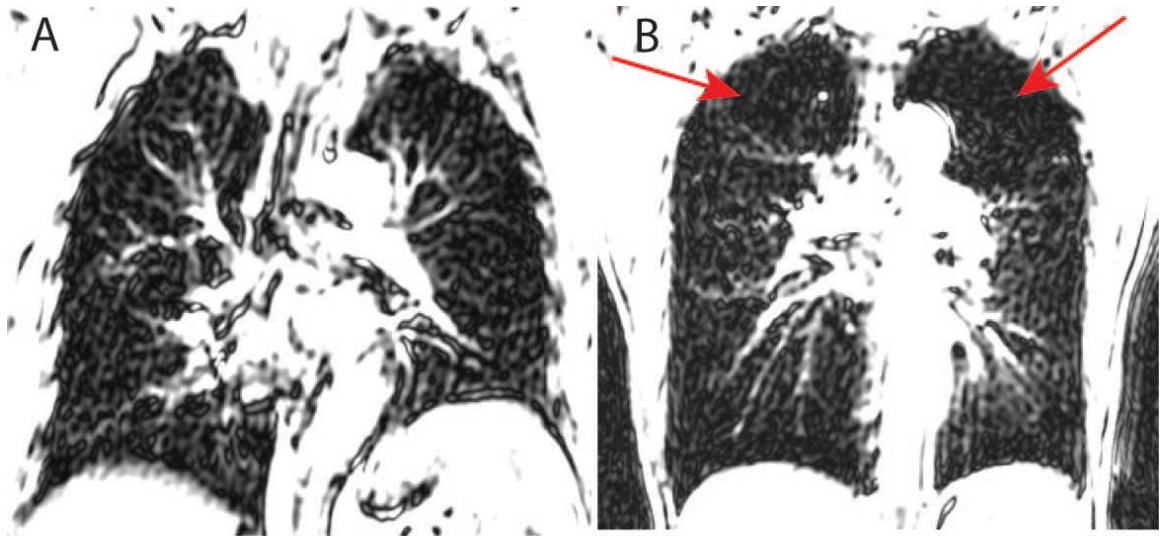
Conventional ^1H MRI of healthy and emphysematous lungs
